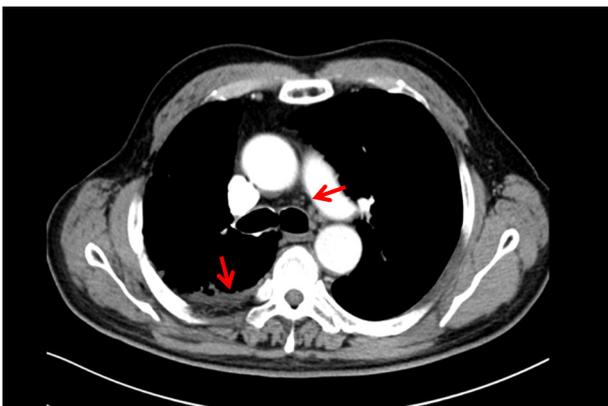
Postoperative chest computed tomography scan of the primary lesion. The red arrow on the left indicates pleural effusion, while the red arrow on the right denotes mediastinal lymphadenopathy.
